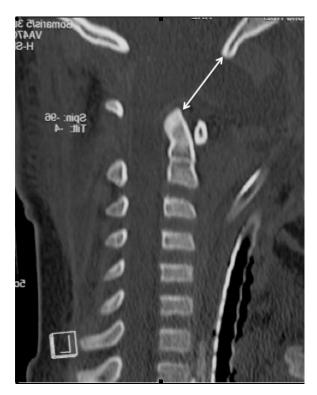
Mid-sagittal reformatted computed tomography scan of the cervical spine in the bone window setting demonstrates widening of the atlanto-occipital joint with a basiondens interval (arrow) measuring 25 mm.
